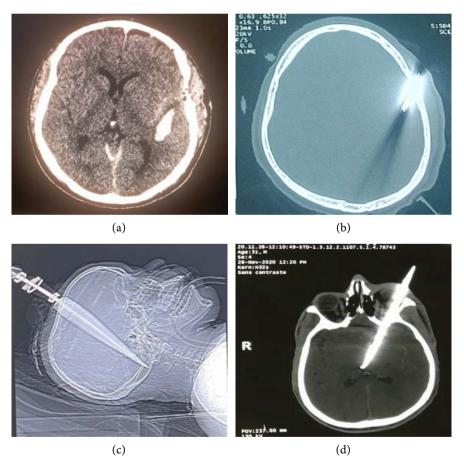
Cerebral CT scan: (a): Parenchymal window in axial section showing an intraparenchymal hematoma; (b): Bone window in axial section showing a fracture with a penetrating object embedded in the skull; (c): Bone window in sagittal reconstruction showing a knife penetrating to the occiput; (d): Parenchymal window in axial section showing an arrow-like penetrating object in the right orbit. On admission, all patients received tetanus serum combined with tetanus vaccine, and double antibiotic therapy (ceftriaxone 4 g/day and metronidazole 1.5 g/day) for a minimum of 10 days and a maximum of 21 days. A total of 9 patients, or 75% of cases, were admitted to intensive care, including 3 patients admitted intubated in poor hemodynamic condition.
